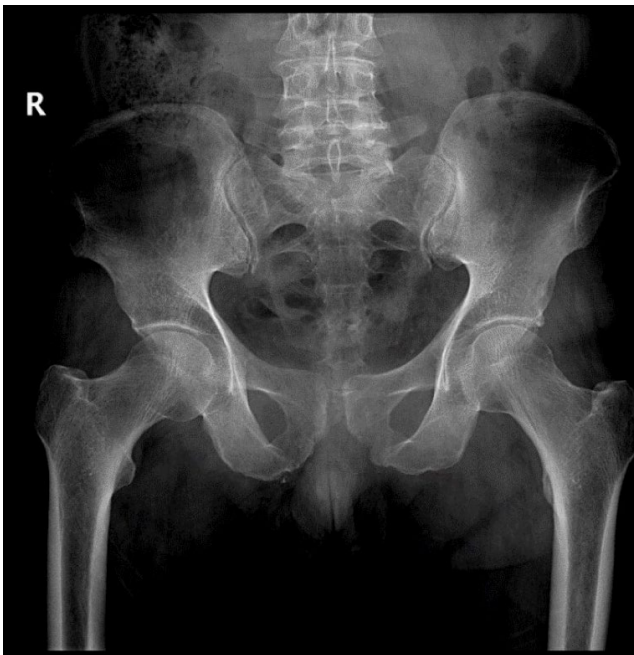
Anteroposterior radiograph of pelvis showing joint border irregularities and joint space widening.
